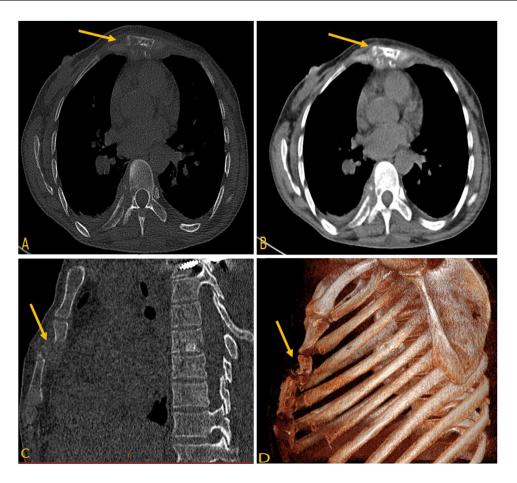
Computed tomography axial section bone center (A), mediastinal window (B), sagittal section (C) and 3D section (D) showing an osteolytic tissue mass centered on the sternum with sternal fracture (orange arrow).
